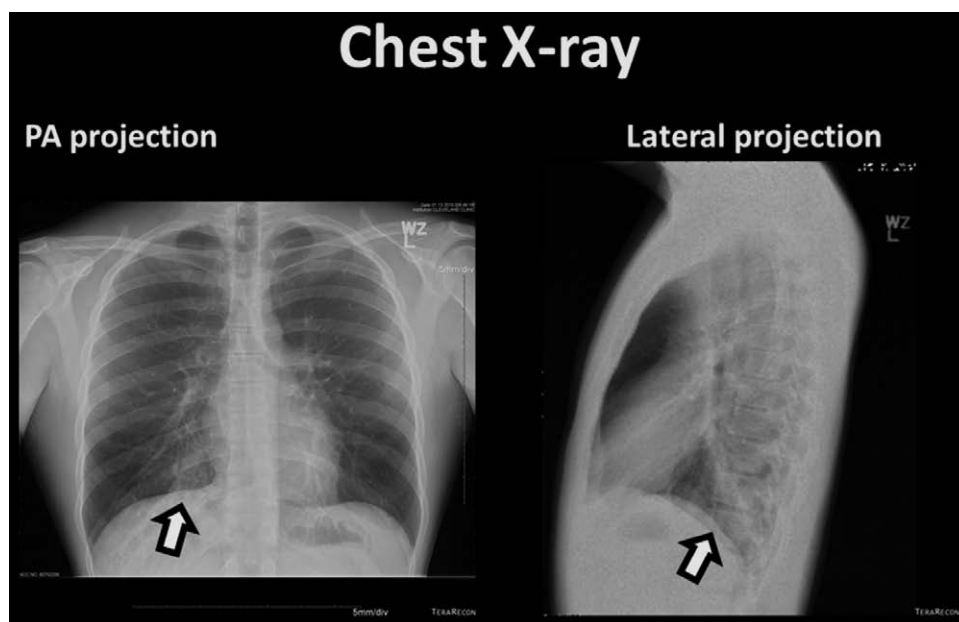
Chest x-ray (posterior-anterior and lateral projections) revealing conglomeration of tubular densities in a scimitar pattern in the right lower lobe (arrow).
